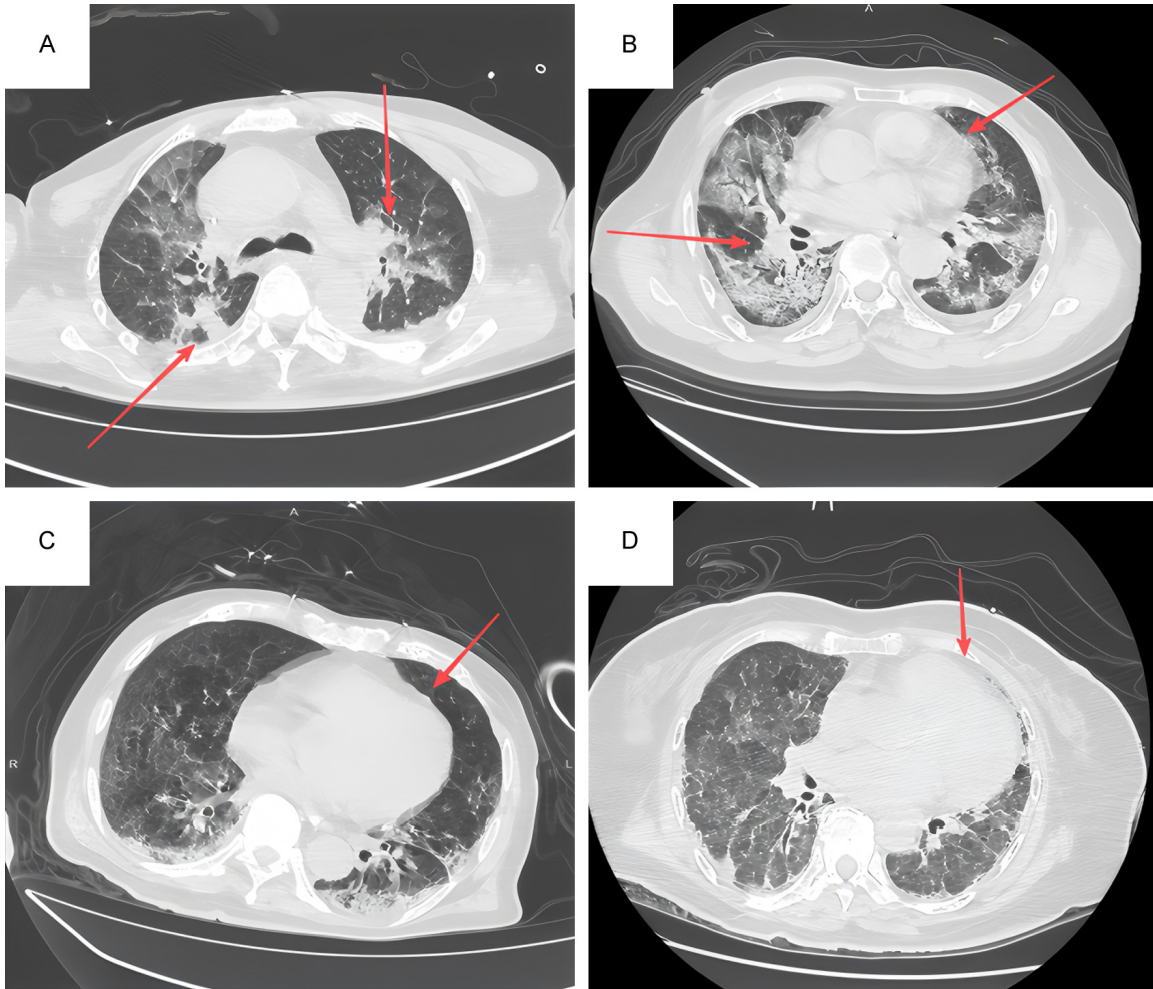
Chest imaging findings of severe pneumonia patients in this study. A. Chest CT: Bronchial lesions with multiple infections, partial consolidation in bilateral lower lobes, small pleural effusions, and subsegmental atelectasis. B. Chest CT: Progressed bronchial and infectious lesions, right middle lobe syndrome, calcified nodule in right lower lobe, cardiac enlargement, coronary artery calcification, mediastinal lymph nodes, and pleural thickening. C. Chest CT: Extensive progressive infection, chronic bronchitis with emphysema, aortic calcification, and pleural thickening/adhesion. D. Chest CT: Diffuse multifocal viral pneumonia-like lesions (subpleural predominant), cardiac enlargement, coronary calcification, and pleural thickening/adhesion.
